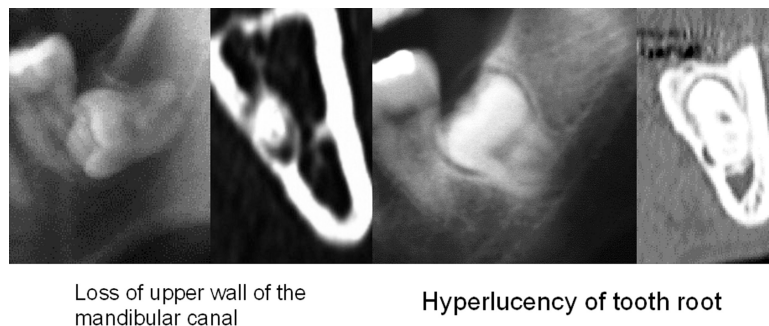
Panoramic radiographs of the third molar root apex and periapex in the presence and absence of a bone wall, as shown in Tooth-Pix™ images.
